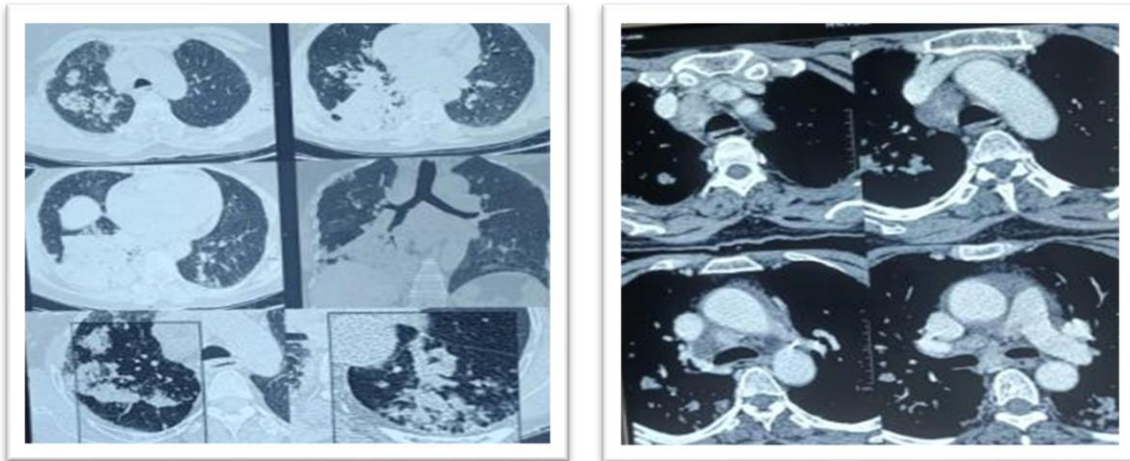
CT scan of the chest on May 2023 showing worsening lung opacification and increased lymph node size
